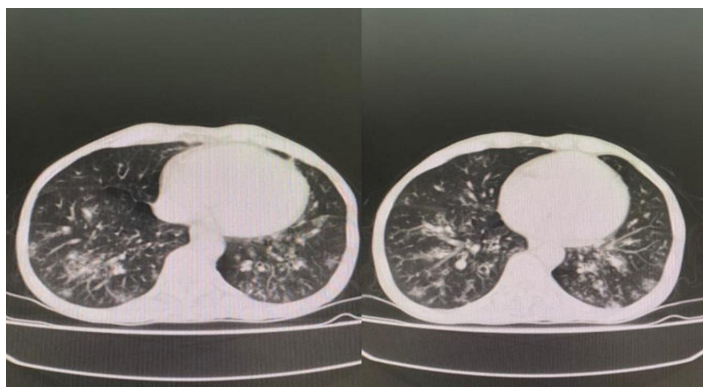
Suspicious viral pneumonia view on thoracic CT
